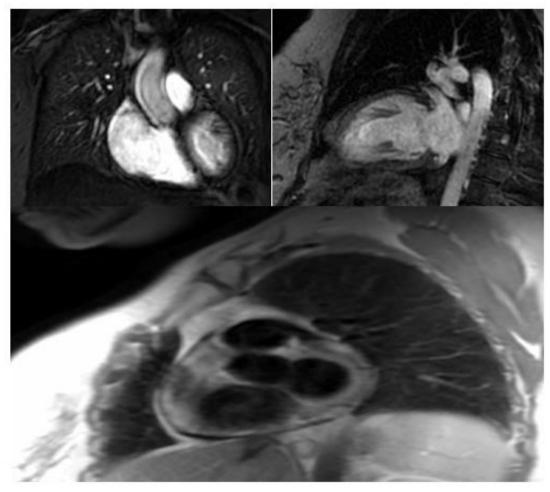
MRI shows Normal LV and RV size and systolic function, no abnormal enhancement of the LV or RV myocardium, mild RA and LA enlargement, any significant valve lesion, pericardium is of normal thickness with no pericardial enhancement
